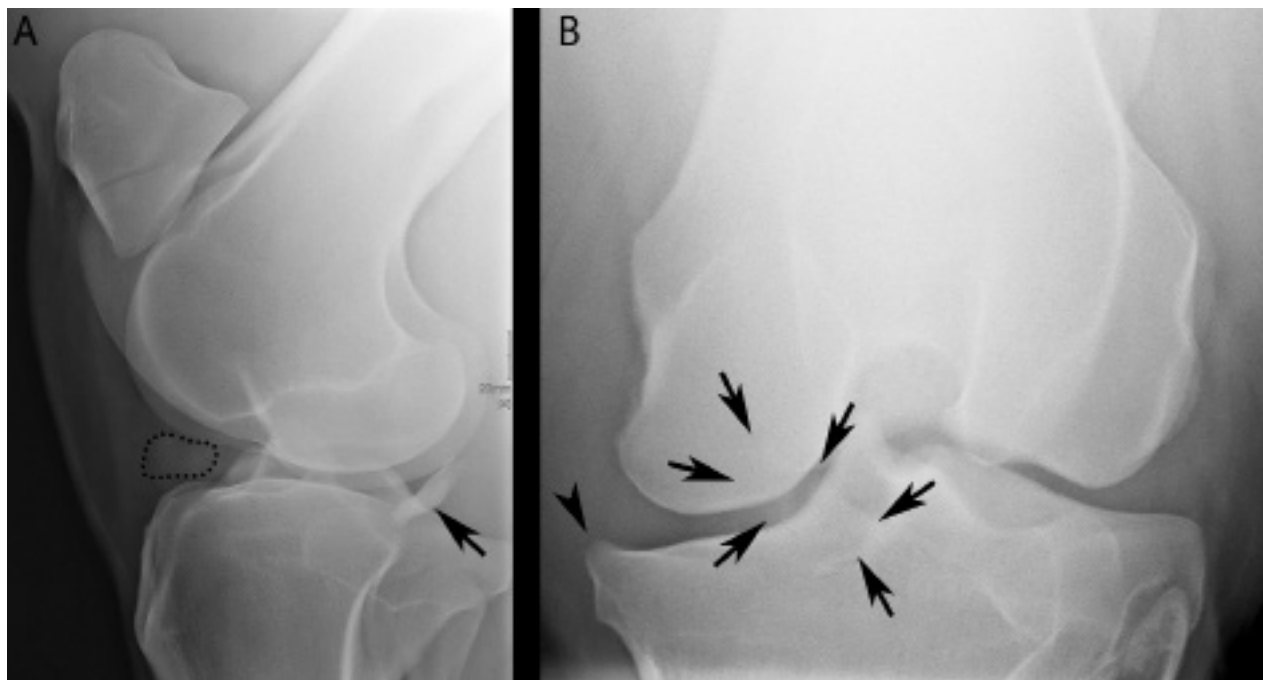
Same radiographic images as in Figure 1. A well-defined bone fragment (arrows) caudodistal to the medial femoral condyle is evident, more so on the lateromedial image (A) than the caudocranial image (B). The cranial aspect of the stifle joint has an area of increased opacity (dotted outline), and there is moderate osteophyte formation (arrowhead) on the medial aspect of the medial tibial condyle and medial femoral condyle.
